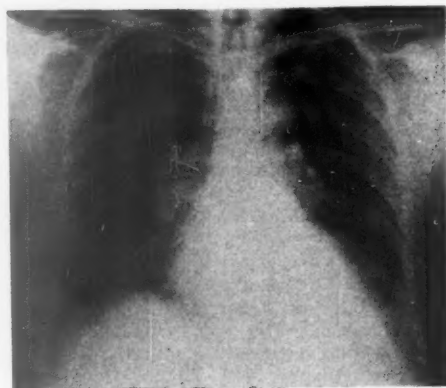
Chest X-ray 12.1.60.
